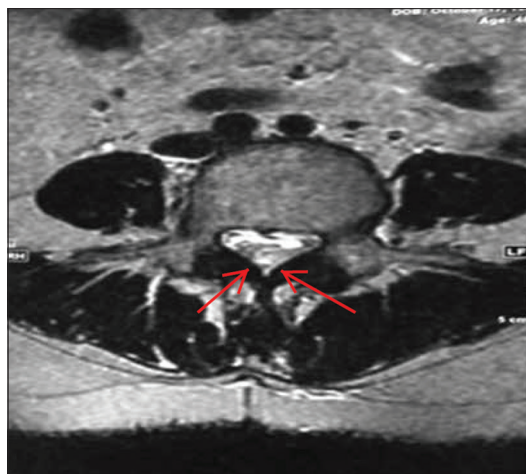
Axial T2-weighted images of L2–L4 hematoma. (Images obtained from John H. Stroger Jr, Hospital of Cook County, Department of Radiology 2015)
